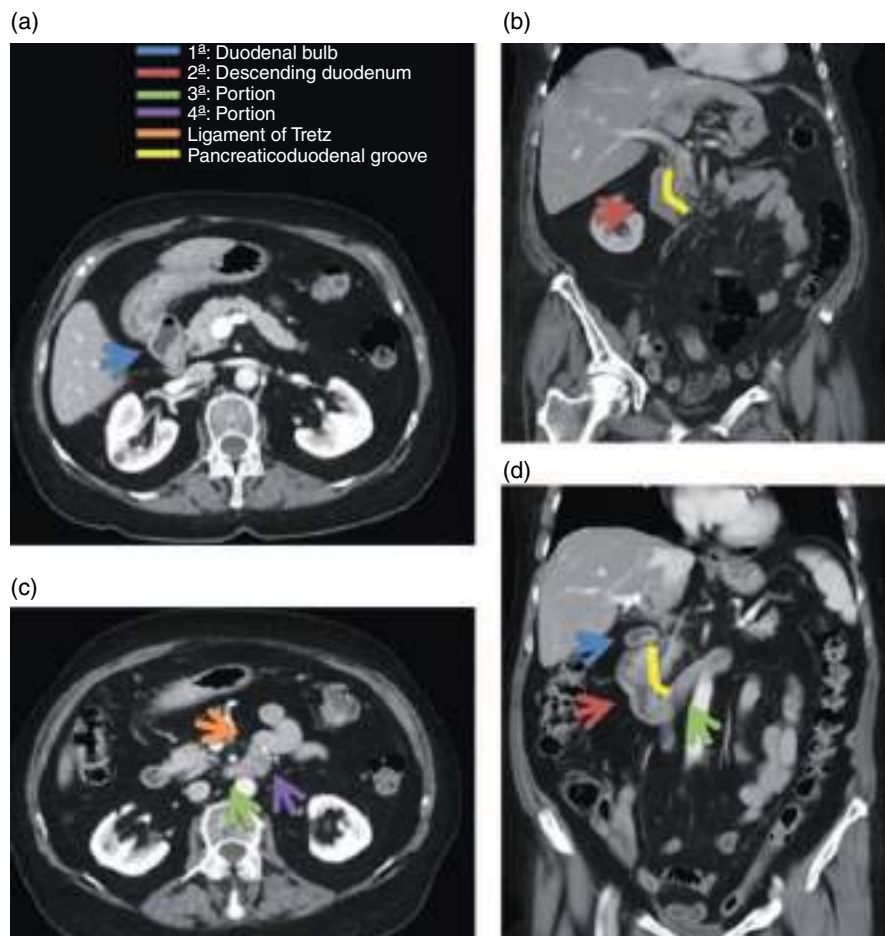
Duodenum. (a, c) Axial contrast-enhanced CT image (portal venous phase). (b, d) Coronal contrast-enhanced MPR CT image (portal venous phase).
